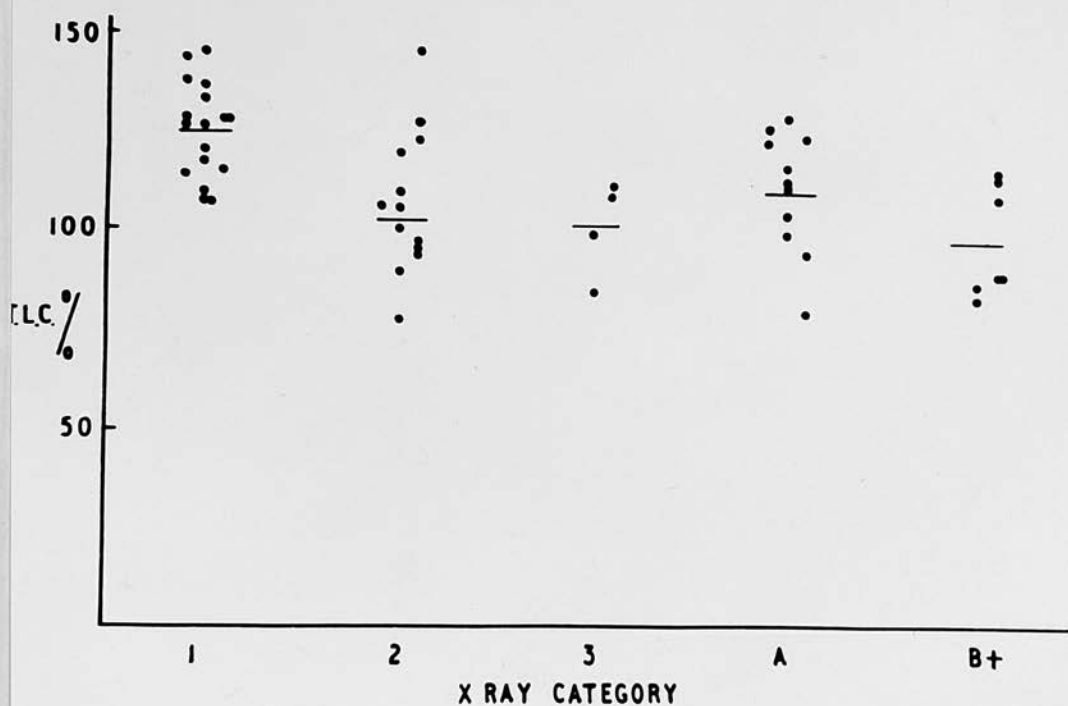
shows the relationship between T.L.C.% and the X-ray categories.
